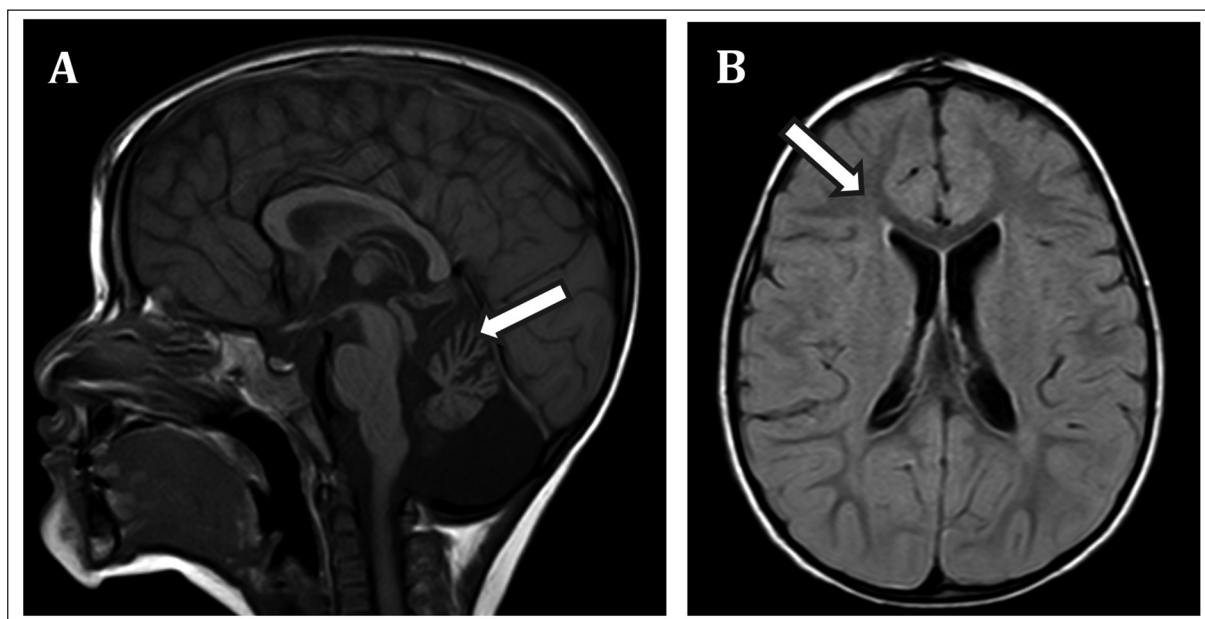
Brain magnetic resonance imaging showing atrophy of the superior aspect of both cerebellar hemispheres and the vermis, with mild widening of the interfolial spaces on sagittal T1-weighted images (A). Mild signal abnormalities in the bilateral periventricular and deep frontoparietal white matter on axial T2/FLAIR sequences, considered nonspecific (B).
